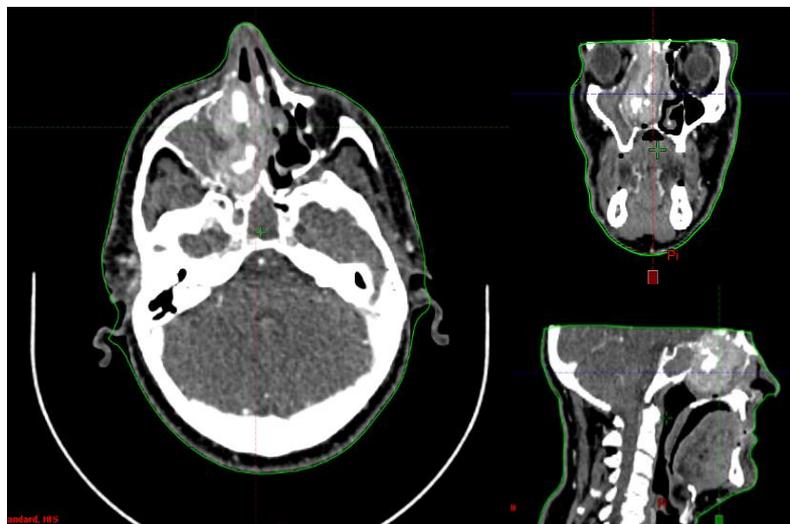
Cervico facial CT scan in three distinct sections showing a right ethmoid lesion with lysis of the roof and papyraceous lamina
